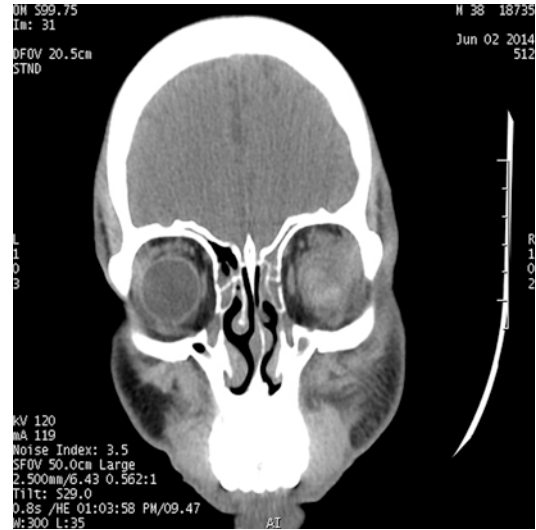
CT scan showing a ruptured right eyeball. Note small eyeball with irregular ocular coats
